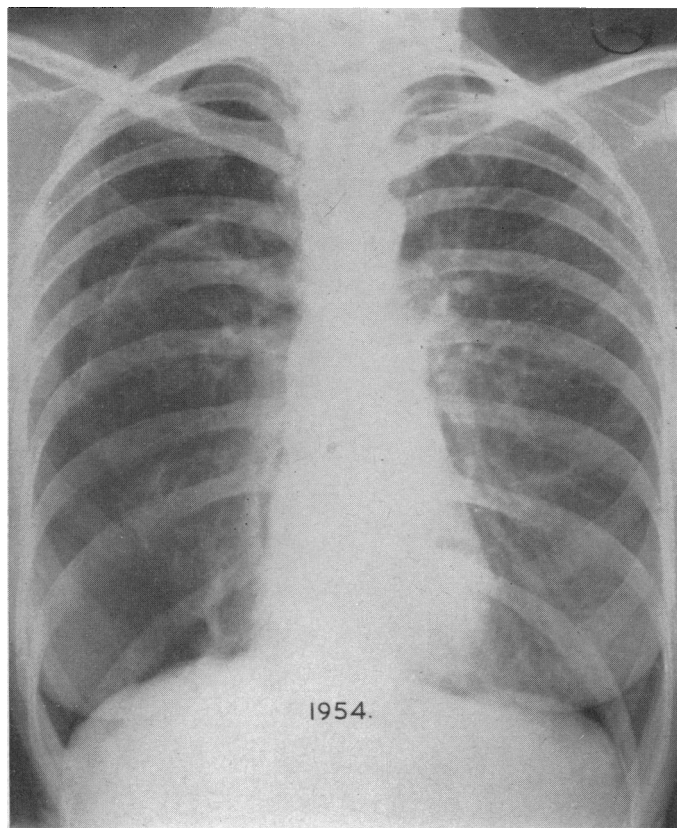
Radiograph (1954). Right-sided pneumothorax and apical adhesions. Left lung clear.
